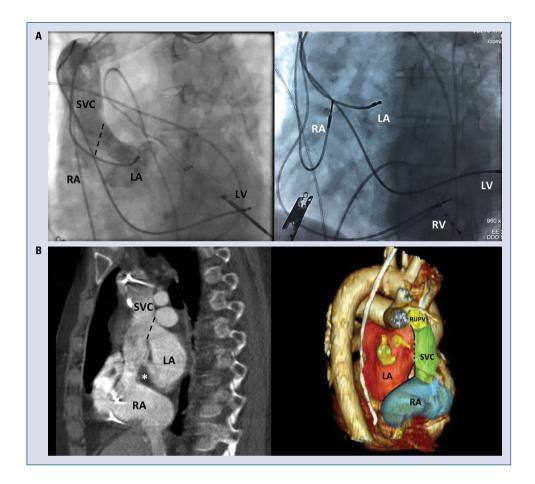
A. Superior vena cava (SVC) selective angiography (left) showing shunt between right and left atria through the sinus venosus atrial septal defect (SVASD) and left anterior oblique fluoroscopy (right) showing four leads temporarily present in four chambers of the heart; B. Chest computed tomography scan: sagittal plane (left) showing SVASD (dashed line) at the upper most part of inter atrial septum (asterisk) with SVC overriding the defect and three-dimensional reconstruction (right) showing the position of the superior SVASD (dotted black line) and abnormal drainage of the right upper pulmonary vein (RUPV) to the SVC. Left atrium (LA) in red, right atrium (RA) in blue, SVC in green and RUPVs in yellow; LV — left ventricle; RV — right ventricle.
